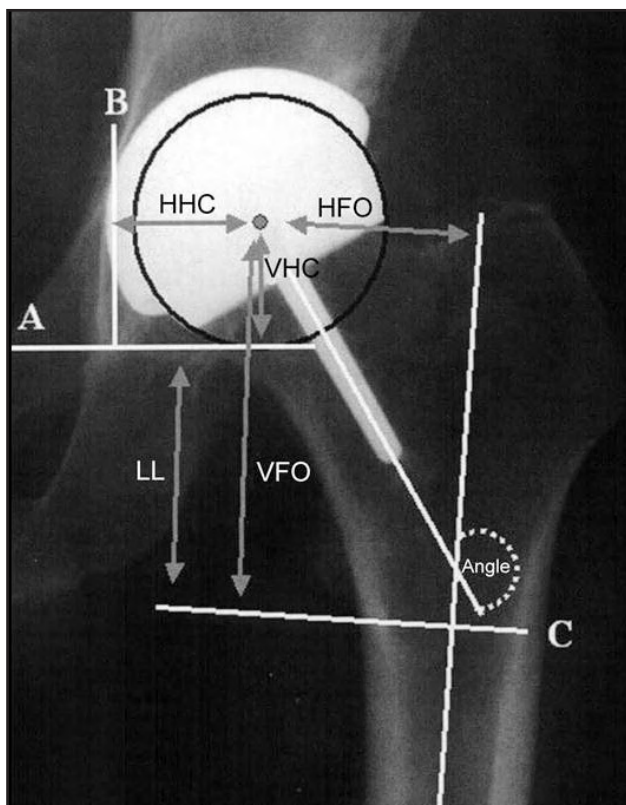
Various parameters measured from plain radiographs of the proximal femur following resurfacing hip arthroplasty.
